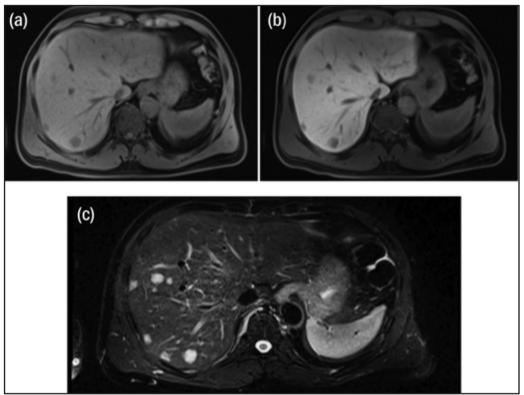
(a) & (b): T1 weighted MRI images showing multiple foci of hypointensity with background of normal liver parenchyma, (c): T2 weighted MRI demonstrated a diffuse nature of the lesions which are hyperintense with different sizes but non-coalescing.
